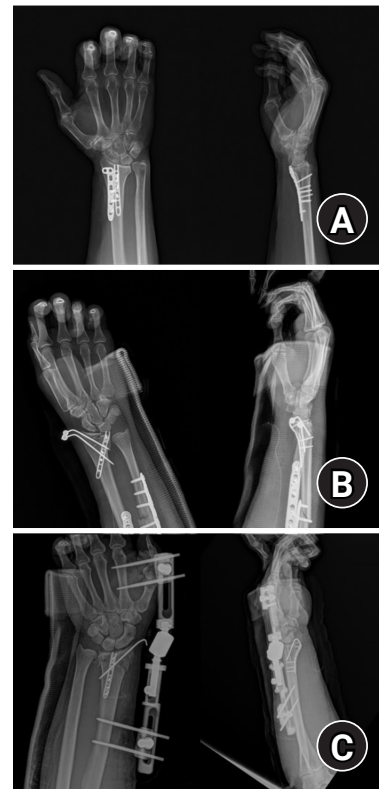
Postoperative radiographs (anteroposterior and lateral). (A) Volar articular marginal fragment of the distal radius fixed by two plates: a standard 2.4 mm LCP-L distal radius plate (Synthes) and a 2.0 mm locking compression plate distal ulnar hook plate (Synthes). (B) Additional percutaneous pinning after plating. (C) Additional percutaneous pinning and external fixator after plating.
